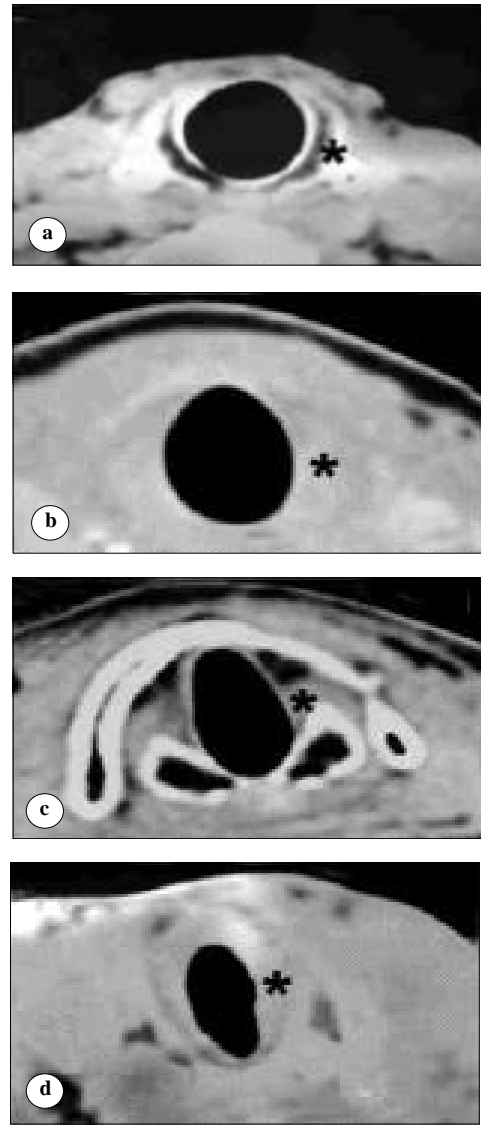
Axial CT scan at the level of the cricoid and cricoarytenoid joint showing different configurations of the cricoid cartilage, (a) Type I: Round, (b) Type II: Oval, (c) Type III: Pear shaped, (d) Type IV: Narrow oblong. (*cricoid cartilage).
